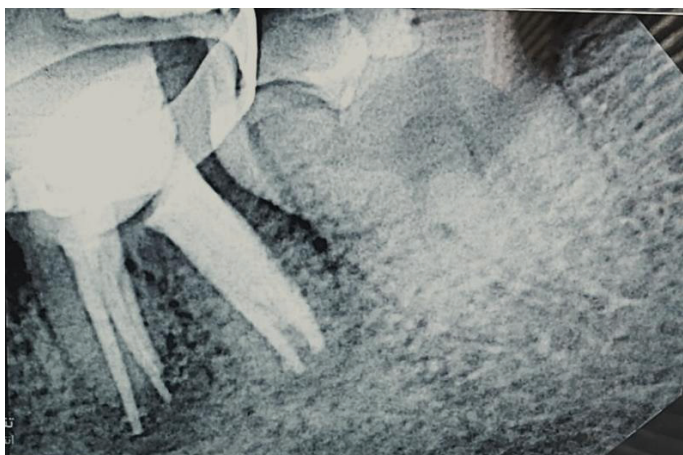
Reevaluation radiograph of the molar
